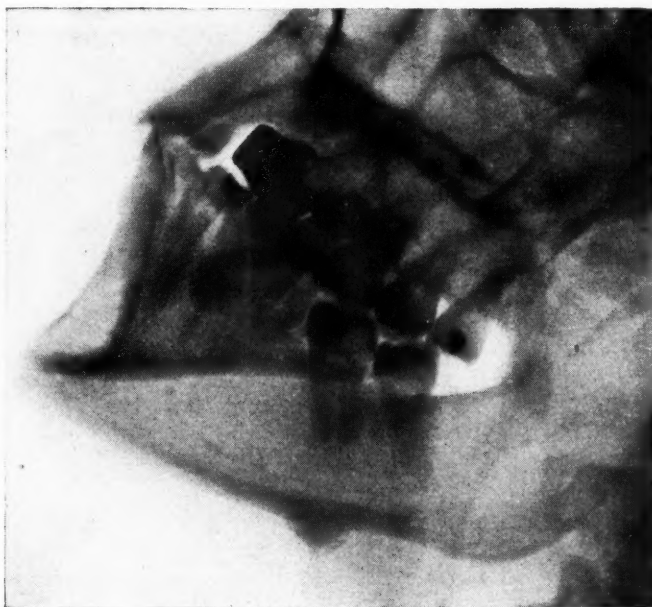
Case 10. Roentgenogram of the tumor of lower margin of mandible.
